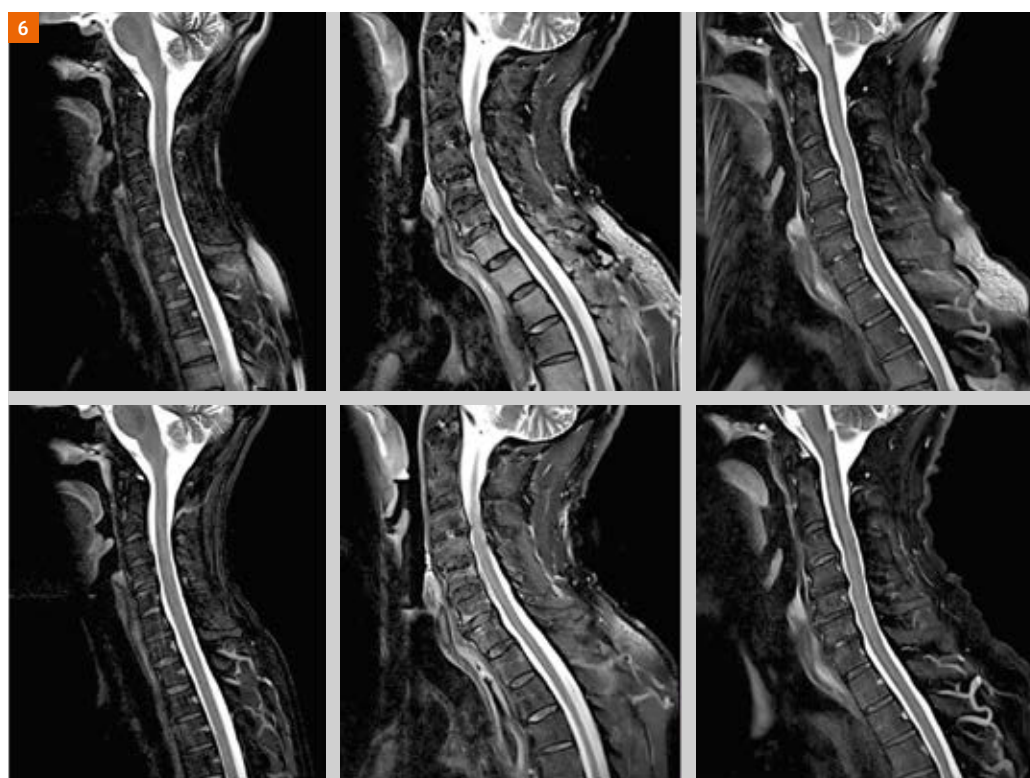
T2-weighted TSE images with SPAIR fat saturation in three different volunteers. Note the intensity gradient within the vertebrae without CoilShim (upper row). The image with active CoilShim on the right shows better homogeneity within the vertebrae and less contribution of unsaturated fatty tissue.
